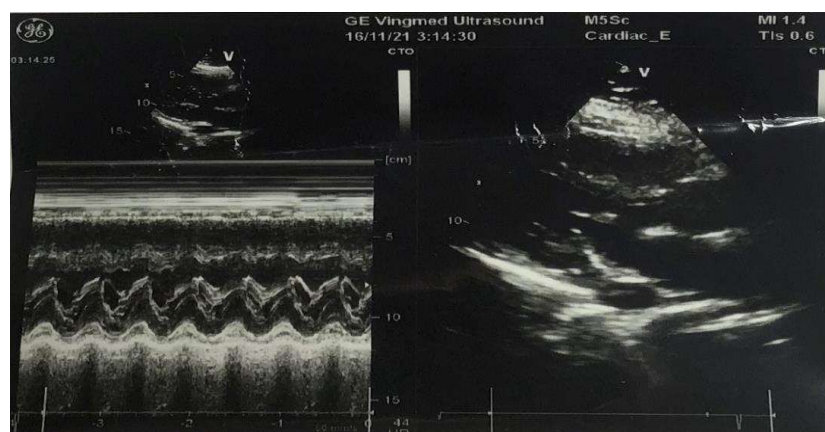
Postoperative echocardiography with parasternal long axis view and M-mode showing normal movement of mitral valve leaflets and proper coaptation.
